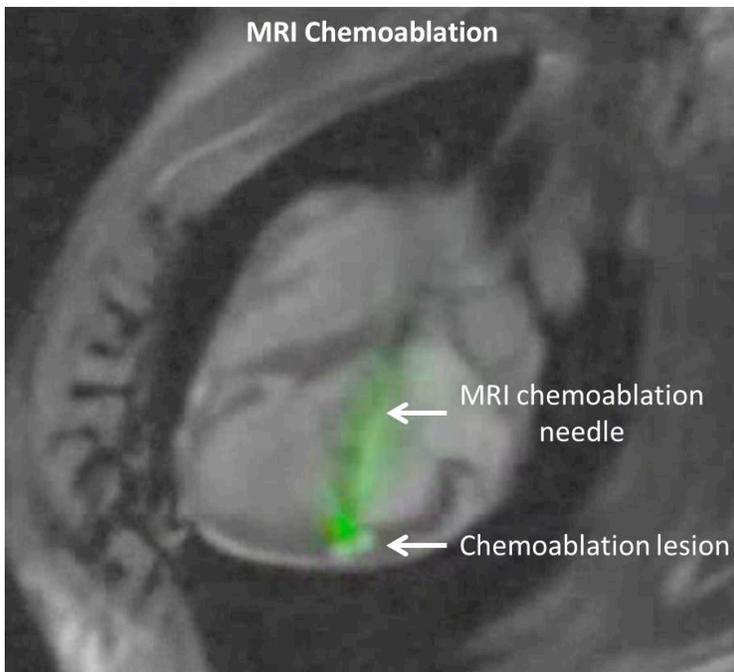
Real time MRI guided chemoablation.
